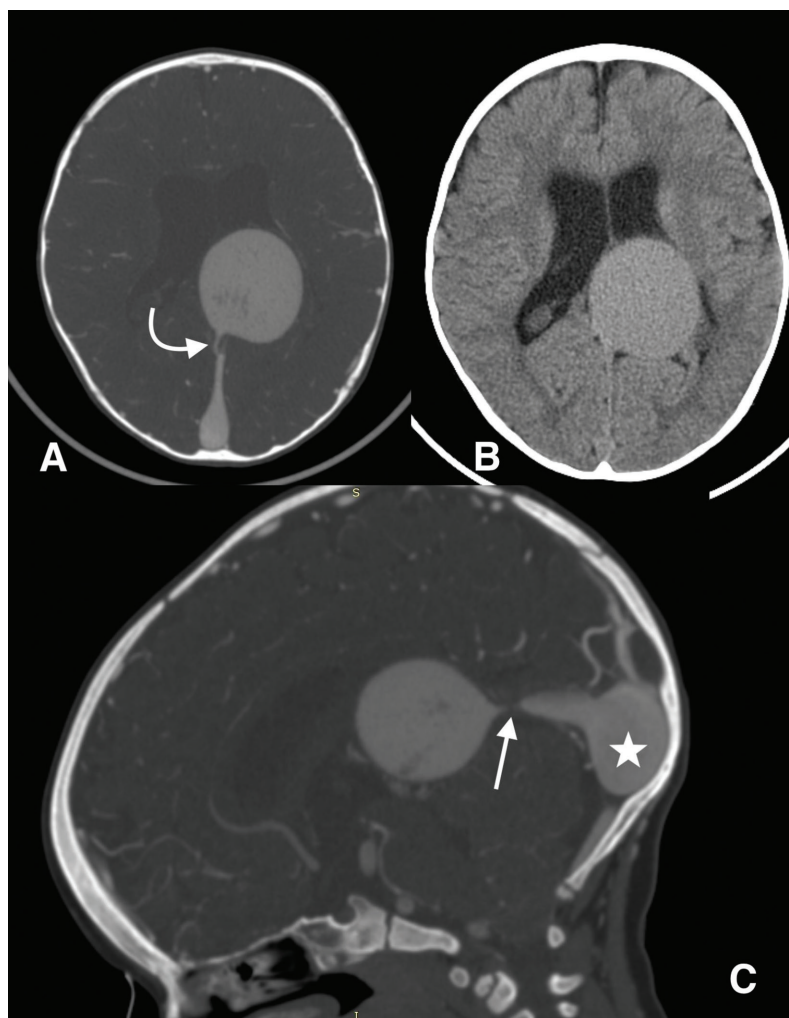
CT image at 1 year. Non-contrast CT demonstrated macrocephaly with elevated biparietal index and dilated lateral ventricles (B). CT angiography shows significant enlargement of the aneurysmal dilated vein of Galen compared to previous MRI, feeders coming from the posterior and middle choroidal arteries draining into it, dilated torcula (white star) and significantly narrowed proximal part of the straight sinus (white arrows) distal to Galen (A, C).
